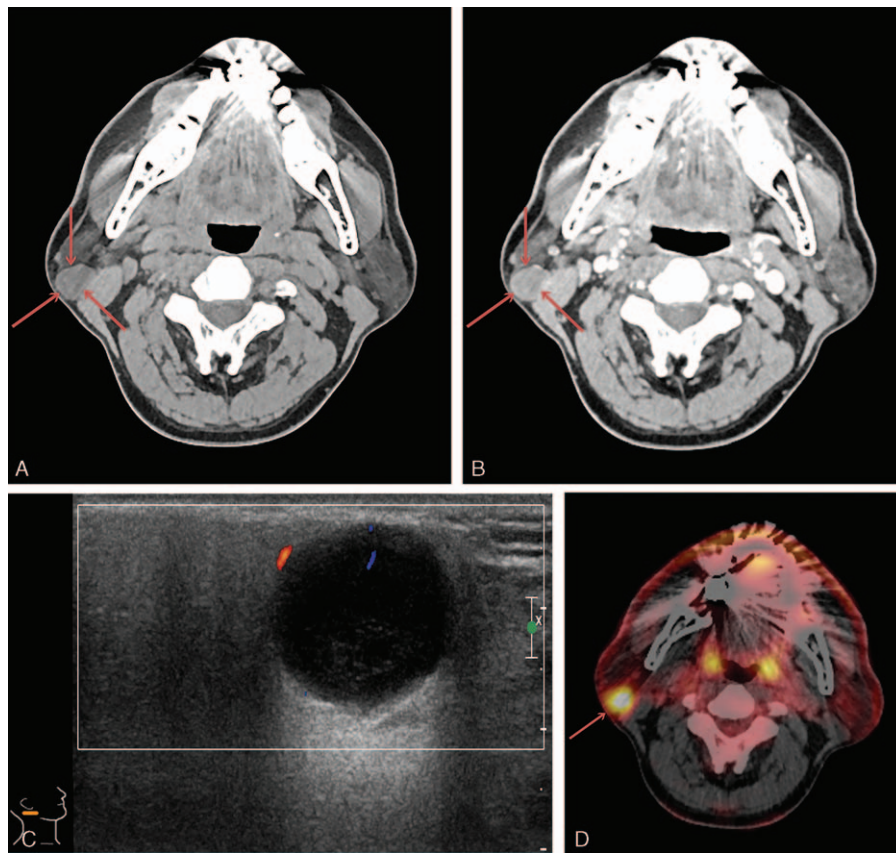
(A) A 44-year-old man presented with a palpable preauricular mass for 1 year. A precontrast computed tomography scan shows a hyperdense homogeneous solid mass compared to the surrounding parotid gland. (B) The mass shows well-defined homogeneous enhancement on a postcontrast scan. (C) Color Doppler ultrasonography shows a well-defined hypoechoic solid mass with posterior enhancement and focal increased vascularity in the hypoechoic mass in the lower portion of the right parotid gland. (D) The mass shows hypermetabolism on a positron emission tomography-computed tomography scan; the maximal SUV was 6.5.
